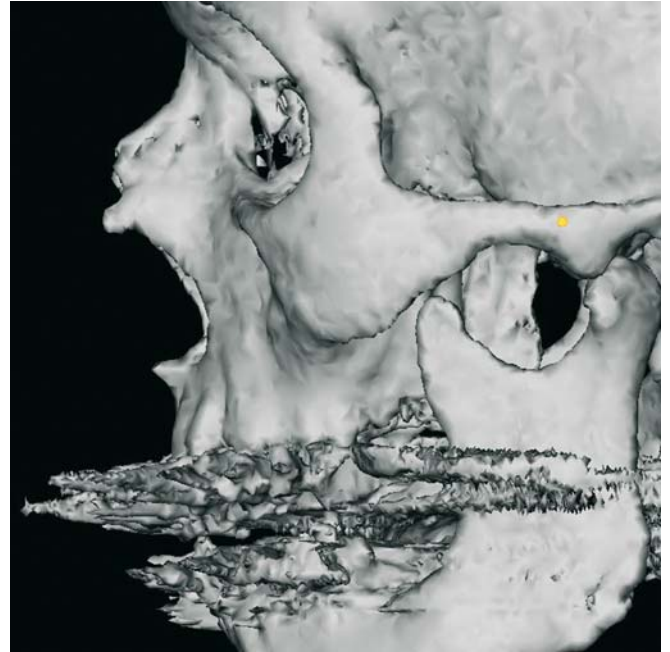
Zygion_l. Profile view left (3-D CT, patient A.G.)
